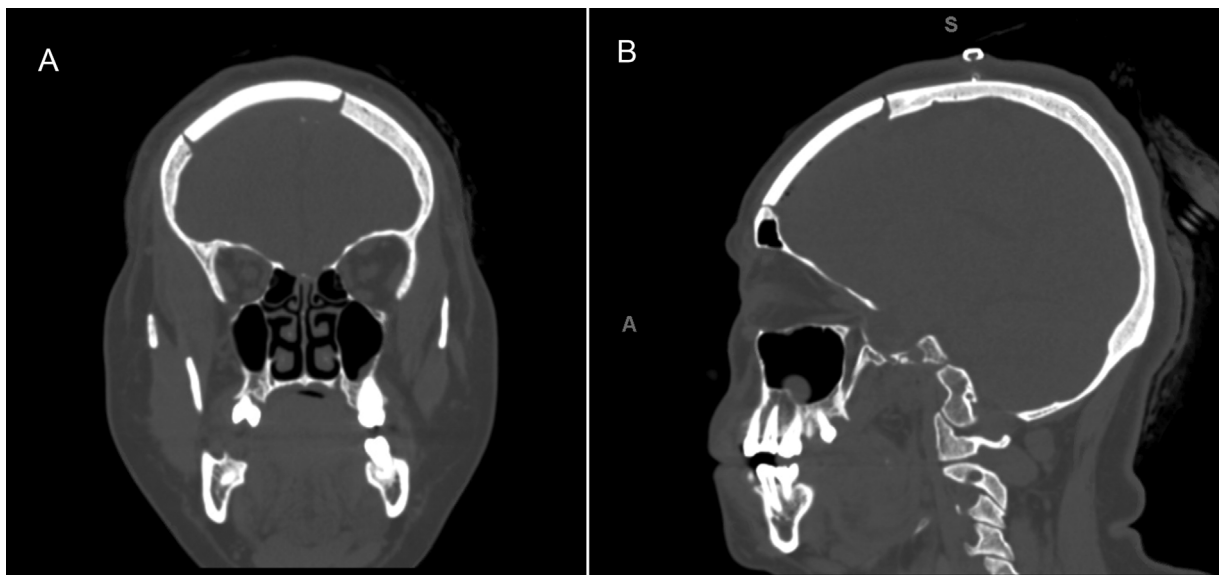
Postoperative computed tomography (CT) coronal (A) and sagittal (B) images after placement of permanent implant 3 weeks after the initial resection.
